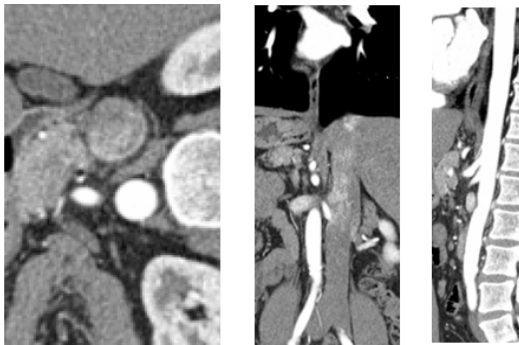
Slices from a MRI DICOM set containing information about the human arteries in the chest and abdominal region that were used as source for the reconstruction process of the aorta and iliac 3D solid model
